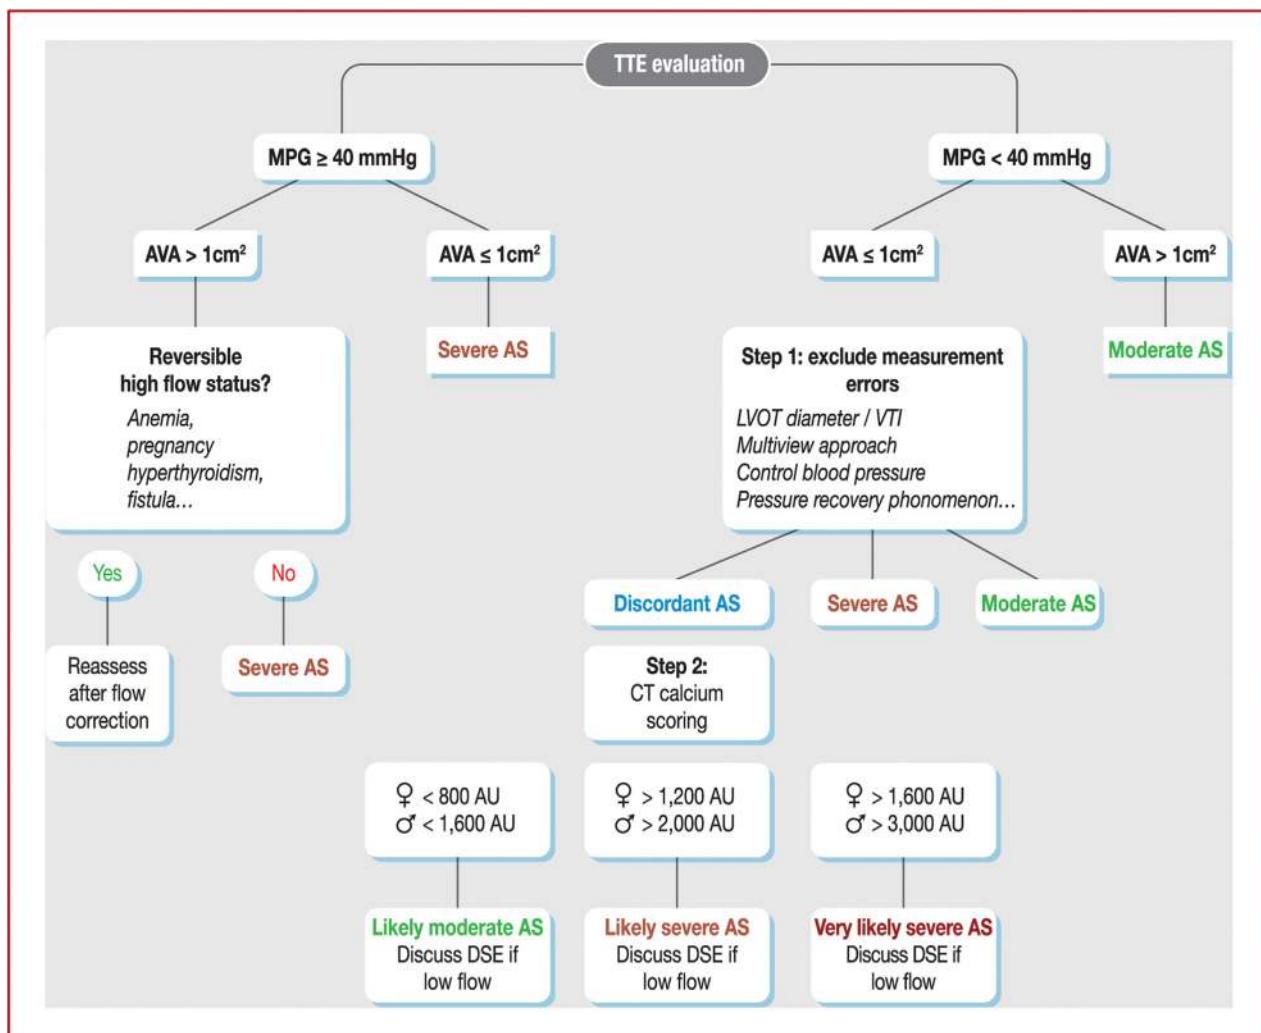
Algorithm proposal for assessing aortic stenosis (AS) severity. AVA: aortic valve area; AU: Agatston unit; CT: computed tomography; DSE: dobutamine stress echocardiography; MPG: mean pressure gradient; LVOT: left ventricular outflow tract; TTE: transthoracic echocardiography; VTI: velocity time integral.
